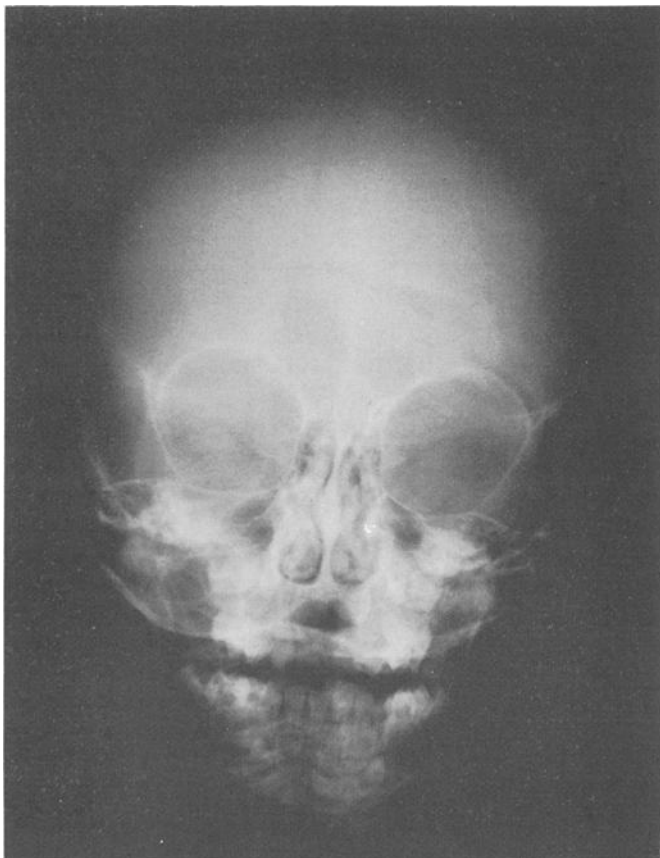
Premortem frontal radiograph of the skull demonstrates one of the surgical defects (arrowheads). The second defect is partially obscured by the left superior orbital rim.
